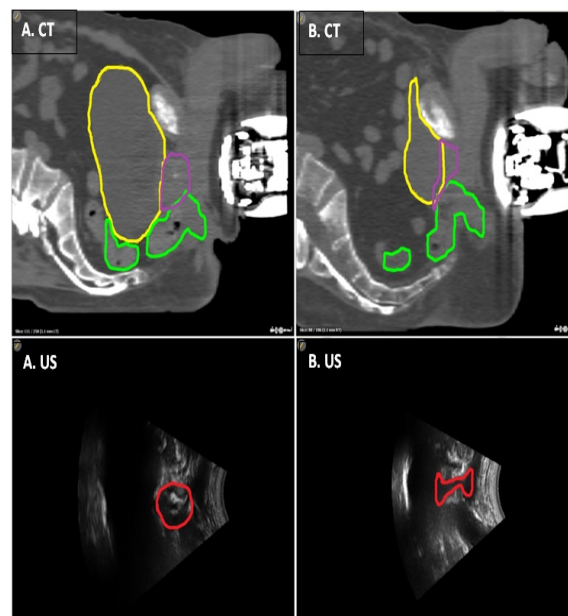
CT and US images of patients treated with in situ prostate (A), and after a prostatectomy (B). Volumes: purple: CTV; red: RPV; yellow: bladder; green: rectum. The RPV corresponds to the prostate volume, for patient A and to the bladder neck plus the urethra, for patient B.
